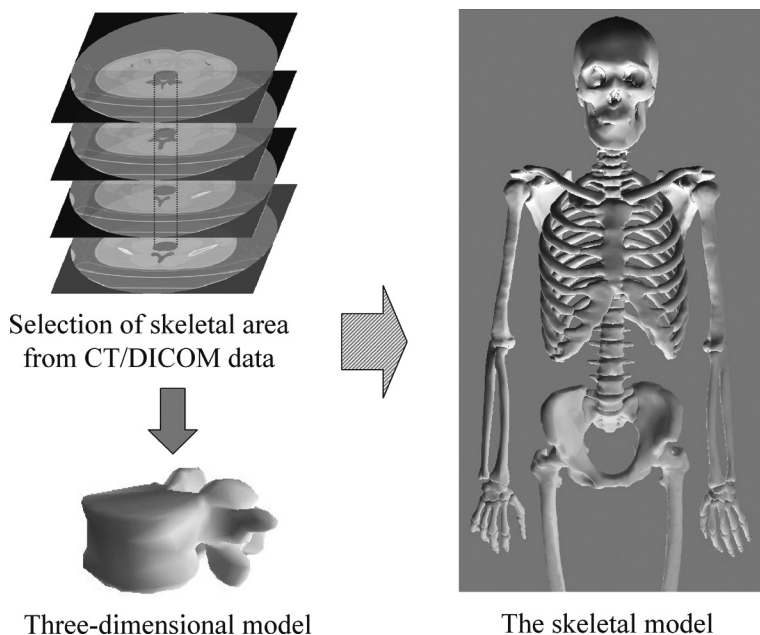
The skeletal model was designed with vertebrae and other segments. The skeletal area was extracted from CT/DICOM data. The three-dimensional skeletal model (i.e., vertebrae, rib, pelvis, etc.) was reconstructed from the extracted area.
